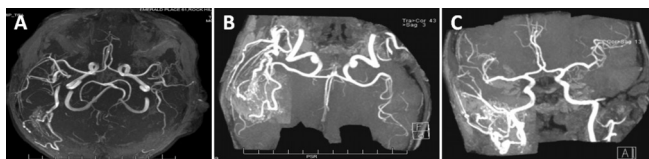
(A) Time of flight (TOF) three-dimensional, multislab, MRI time resolved angiography (TRA) of the brain without contrast. (B) Anterior circulation, tumble view without contrast. (C) Anterior circulation, rotation view without contrast.
